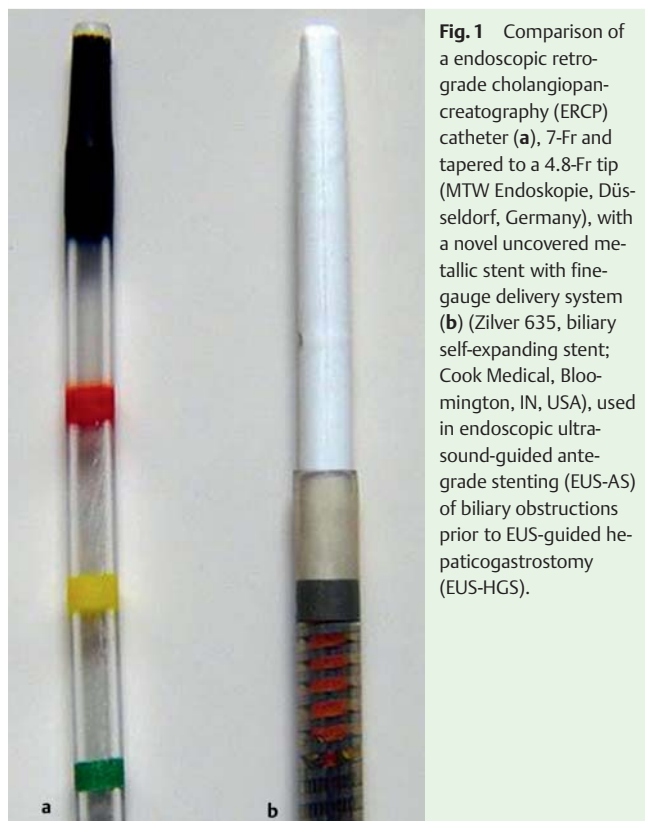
Comparison of a endoscopic retrograde cholangiopancreatography (ERCP) catheter (a), 7-Fr and tapered to a 4.8-Fr tip (MTW Endoskopie, Düsseldorf, Germany), with a novel uncovered metallic stent with fine-gauge delivery system (b) (Zilver 635, biliary self-expanding stent; Cook Medical, Bloomington, IN, USA), used in endoscopic ultrasound-guided antegrade stenting (EUS-AS) of biliary obstructions prior to EUS-guided hepaticogastrostomy (EUS-HGS).
